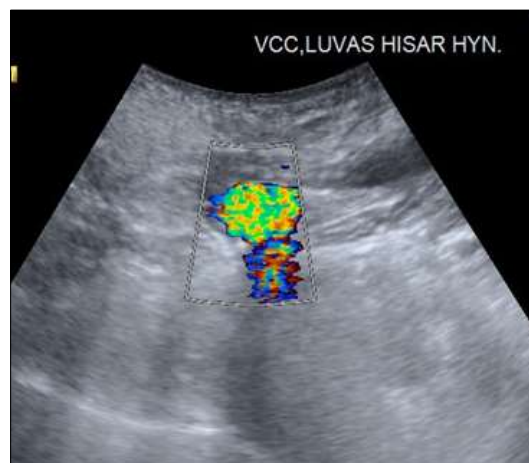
Color doppler ultrasonogram showing vascularity suggestive of urinary bladder tumour
